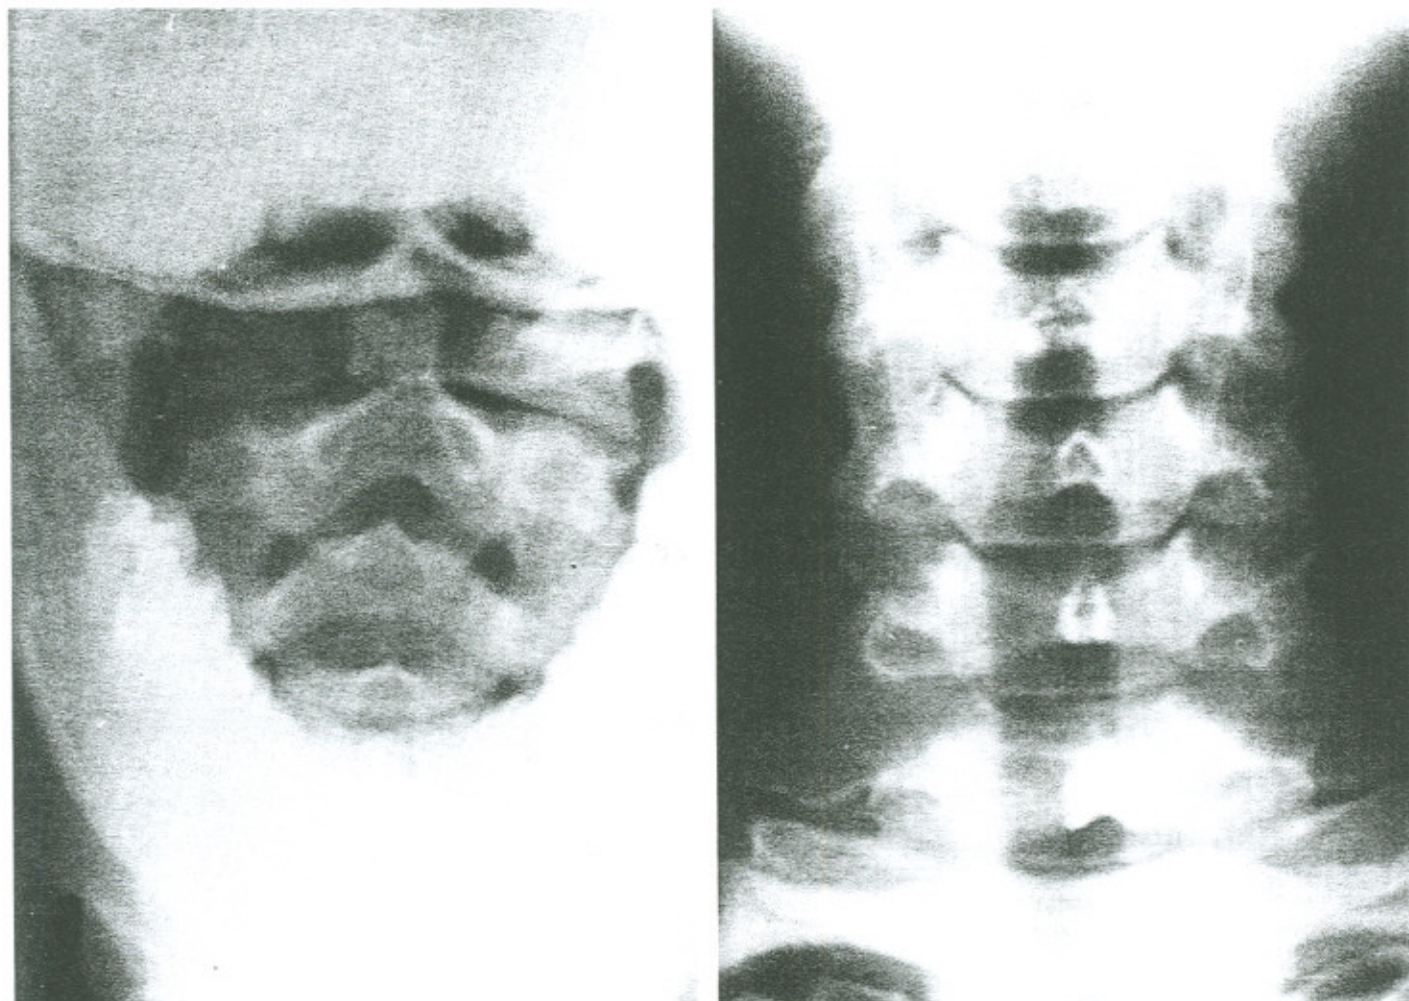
Antero posterior radiographs of the cervical spine of the 32-year-old female presented. Minimal degenerative changes are noted at the intervertebral spaces of C5-C6 and C7-T1.
